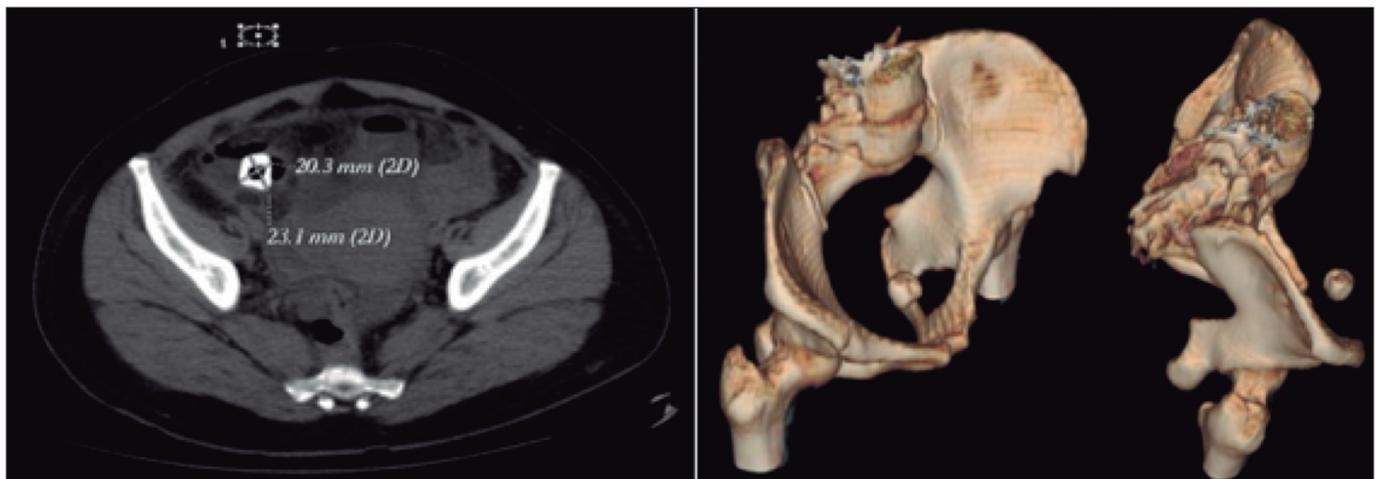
CT scan and reconstruction showing a hyper-dense image on right lower quadrant, suggestive of a fecalith.
